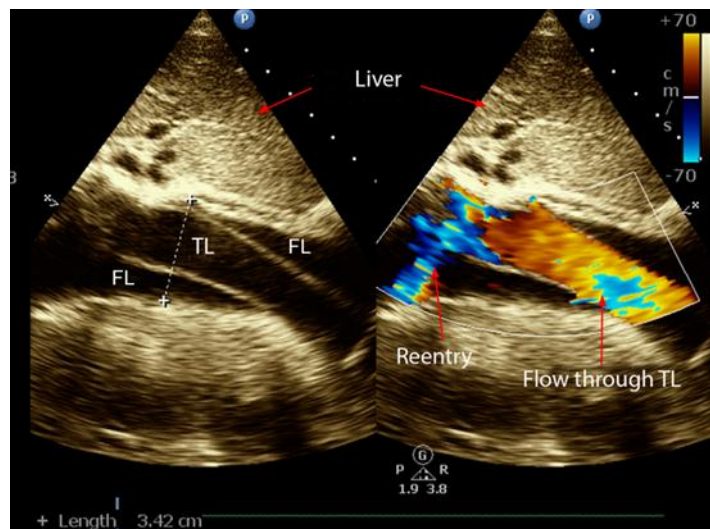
Echocardiogram of the upper abdominal aorta showing the longitudinal axis where the aortic artery is observed with the presence of a double dissection flap with color flow in the true light (TL) and reentry in the posterior region of the false light (FL).
